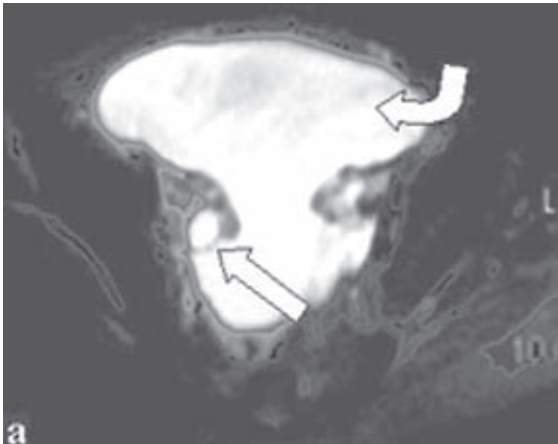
a) Axial T2-weighted image. Right ovarian cyst (straight arrow) and ascites (curved arrow). b) Postcontrast fat-suppressed T1-weighted sagittal image. Abnormal contrast enhancement of peritoneal surfaces (arrows).
